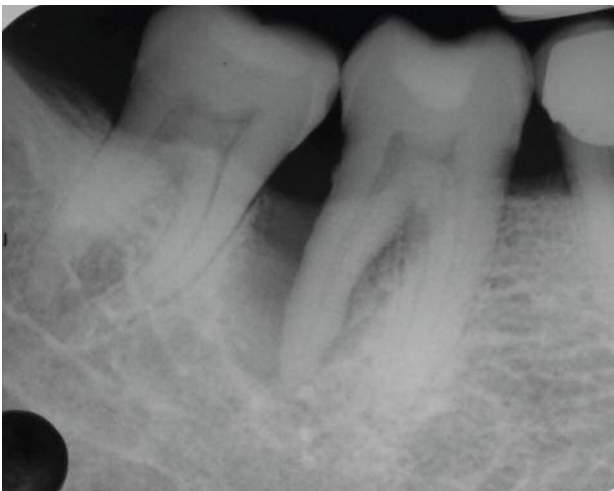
View of the radiographic initial lesion.
